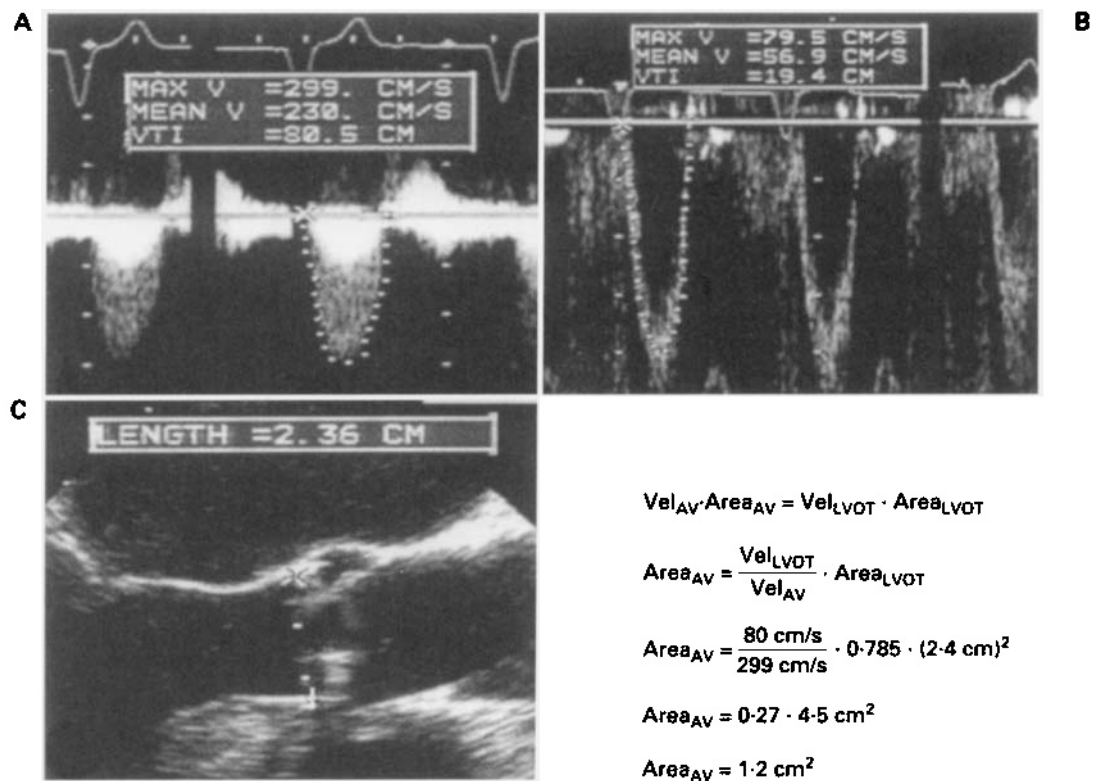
Calculation of aortic valve area (AVA) using the continuity equation. (A) Spectral display of continuous wave Doppler directed through a stenotic aortic valve from the transgastric mid long-axis view. Scale is 100 cm/s between marks. Peak aortic valve velocity is 299 cm/s. (B) Spectral display of pulsed wave Doppler made from the same view as in panel A with the sample volume located in the left ventricular outflow tract (LVOT) just proximal to the aortic valve. Scale is 20 cm/s between marks. Peak LVOT velocity is 80 cm/s. (C) Mid-oesophageal long-axis view of the stenotic aortic valve during systole. The LVOT diameter is 2.4 cm. The equations show calculation of the AVA using these three measurements in the continuity equation.
